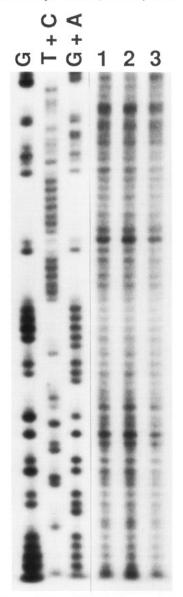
Site specificity of DNA cleavage induced by methylhydrazines plus Cu(II). The ^{32}P 5' end-labeled 98 base pair fragment (AvaI* 2247–PstI 2344) in 200 μ L of 10 mM sodium phosphate buffer at pH 7.9 containing 5 μ M DTPA and 50 μ M per base of sonicated calf thymus DNA was incubated with 20 μ M CuCl₂ and 0.5 mM monomethylhydrazine (lane 1), 1,2-dimethylhydrazine (lane 2) or 1,1-dimethylhydrazine (lane 3) at 37 °C for 10 min. After the piperidine treatment, DNA fragments were electrophoresed on an 8% polyacrylamide–8 M urea gel using a DNA sequencing system, and the autoradiogram was obtained by exposing X-ray film to the gel. The lanes G, G + A, and T + C represent the patterns obtained for the same fragment after cleavage by the procedure of Maxam and Gilbert (1980).
